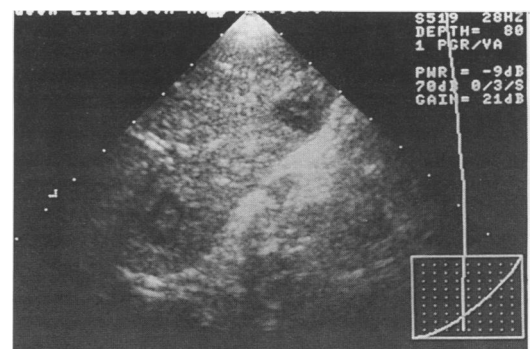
Initial hepatic ultrasound scan showing multiple abscesses.
